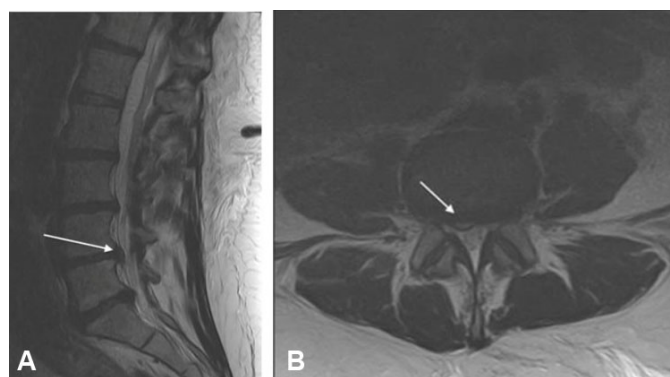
Herniated lumbar disc after spontaneous vaginal delivery. Unenhanced sagittal and axial T2-weighted MRI images of the lumbar spine. The left panel (A) shows a right subarticular disc extrusion at L4-L5 with caudal migration (white arrow), impinging upon the descending right L5 nerve root. The right panel (B) is the axial view at the same level showing the disc extrusion at L4-L5 (white arrow).
